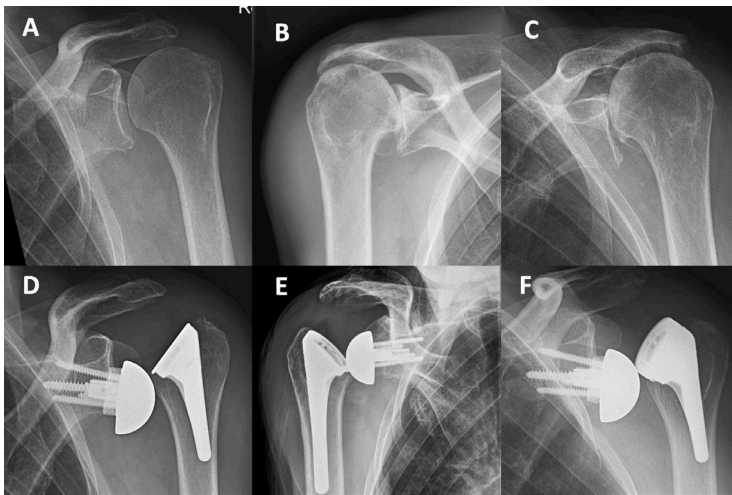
Preoperative radiographs of three patients (A-C) and examples of superior-lateral dislocation of short Perform stems combined with standard non-retentive liners (D-F).
